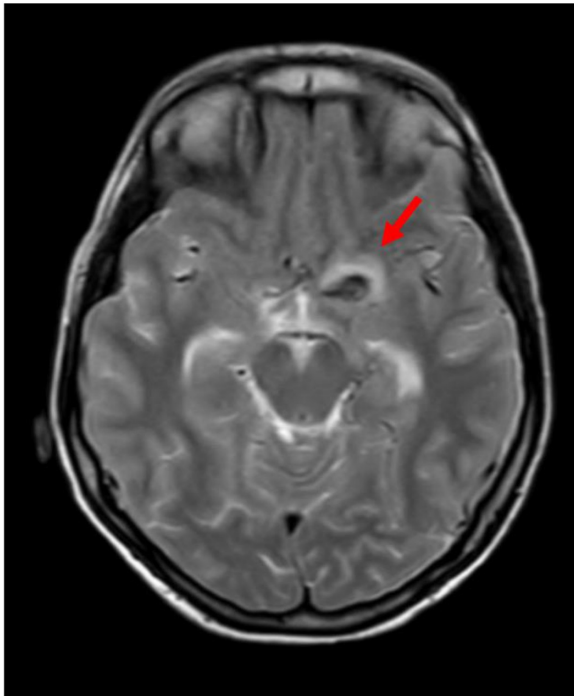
MRI T2-weighted image of brain shows horizontal section of the left internal carotid artery aneurysm.
